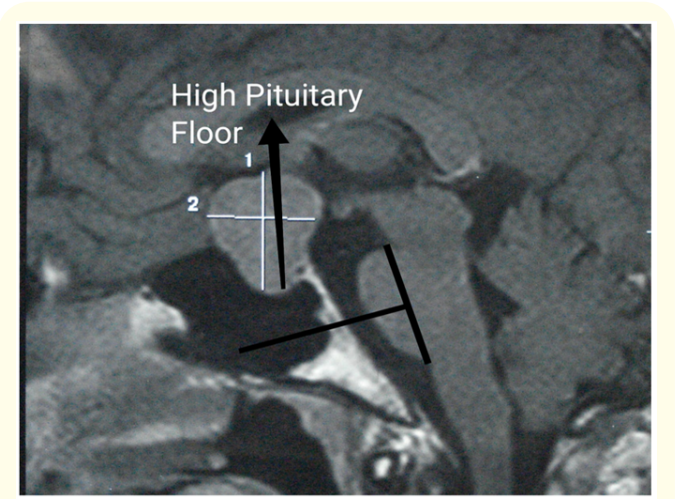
Sagittal MRI Brain shows High Type Pituitary Floor, 11 mms above MPL.
